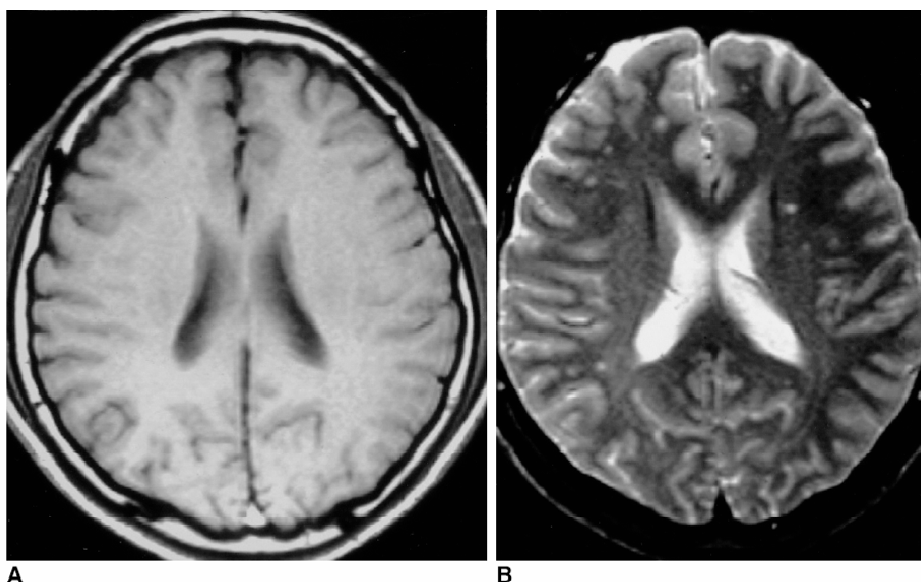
MRI depicting between ten and twenty focal white matter lesions of the frontal lobes in a thirty-four year old participant exposed to carbon disulphide for nine years (A= T1 weighted, B =T2 weighted) (Cha et al., 2002 p.158)
